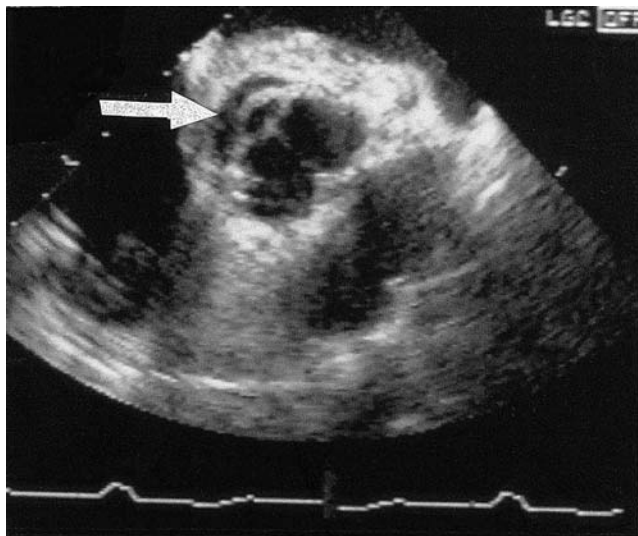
Echocardiographic findings. The arrow indicates the typical clear space introduced between the walls of the native aorta and of the Freestyle valve, when the latter is implanted using the modified subcoronary technique.
